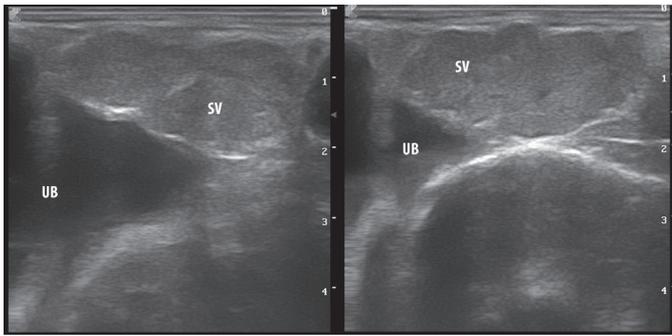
Transrectal ultrasonography of the normal seminal vesicle (note the lobulated aspect of the gland) in a ram. UB= urinary bladder, SV= seminal vesicle
